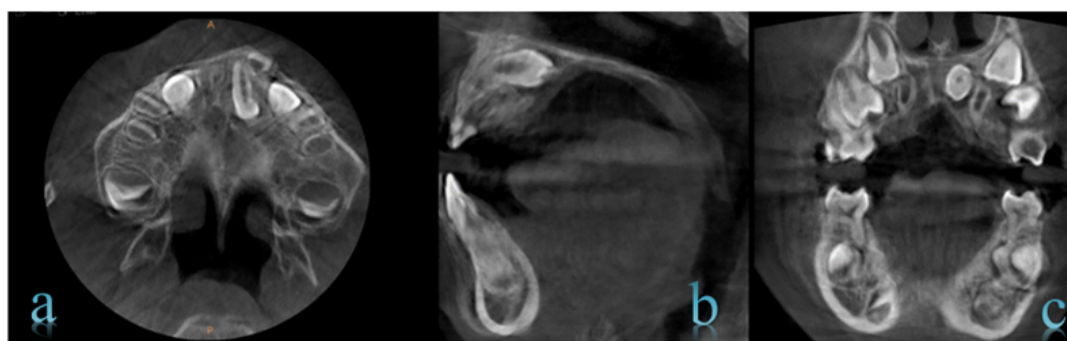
CONE BEAM tomography: a) Axial slice; b) Sagittal slice; c) Coronal slice
